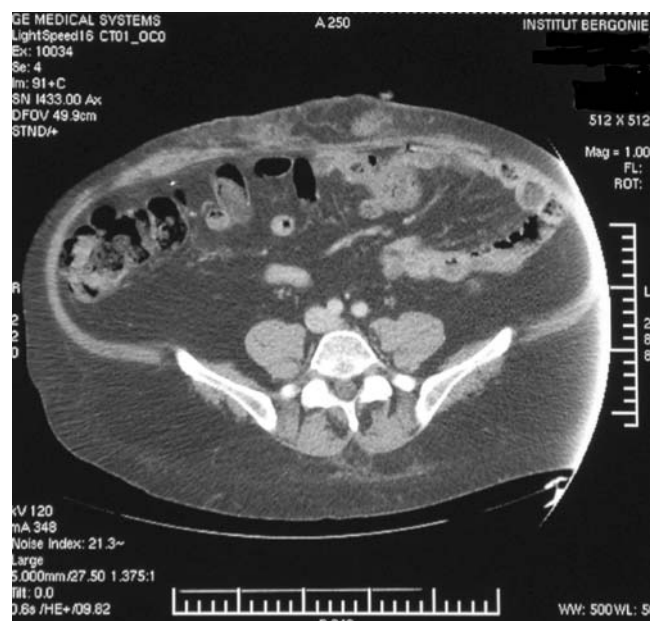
Contrast-enhanced computed tomography scan of abdomen: extensive heterogeneous thickening of the skin and subcutaneous fat, with infiltration of the abdominal musculature
